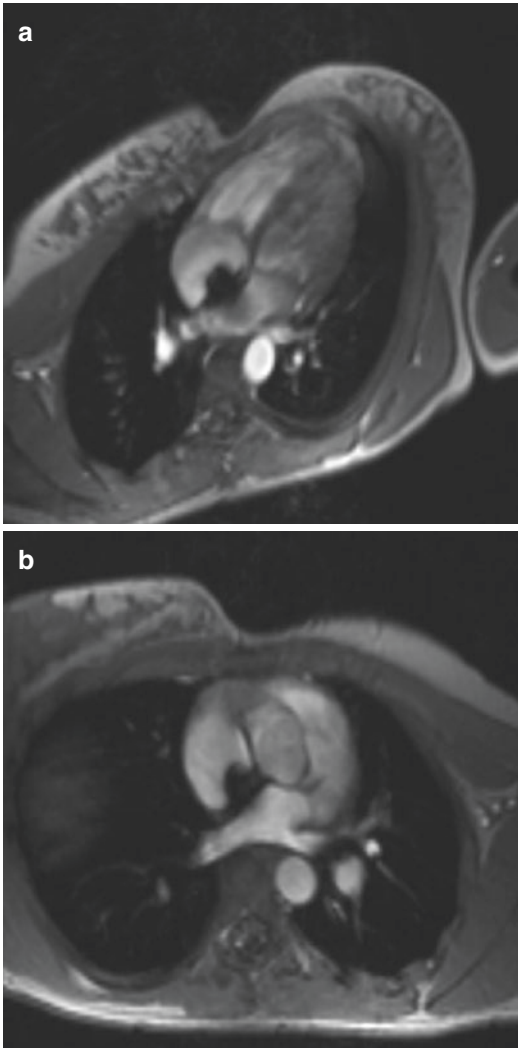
Secundum ASD treated with septal device occluder. MRI obtained 2 years after procedure. Four-chamber view (a) and axial view (b) images of cine FLASH MRI sequence demonstrated an adequate position of septal device occluder for closure of ASD without residual shunt. Note the normal size of the right cardiac chambers
